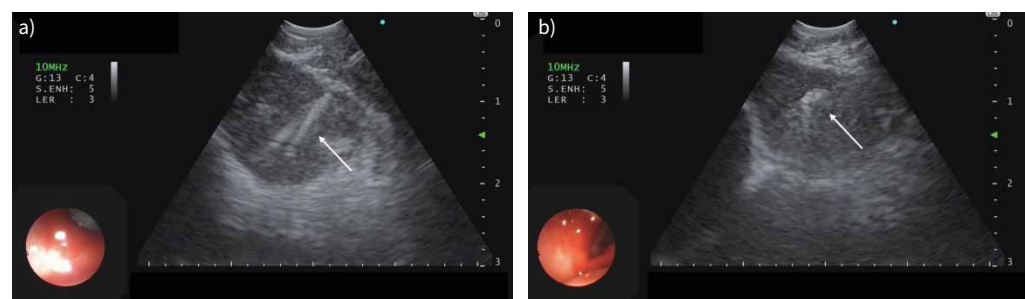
Endobronchial ultrasound (EBUS)-guided transbronchial needle aspiration (TBNA) was performed with 22G TBNA needle for three passes (arrow in a), followed by cryobiopsy placing the 1.1 mm cryoprobe into the target lymph node through the track created by TBNA needle and a high-frequency needle knife (arrow in b).
